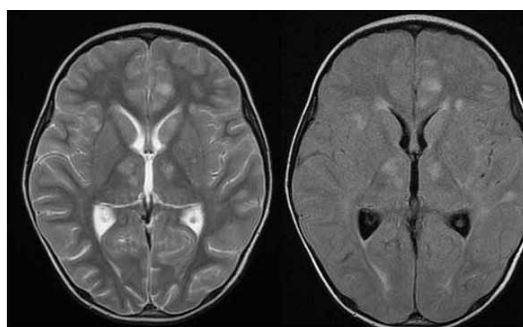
MRI in patient with pneumococcal meningitis demonstrating multiple vasculitic lesions (case was excluded).
